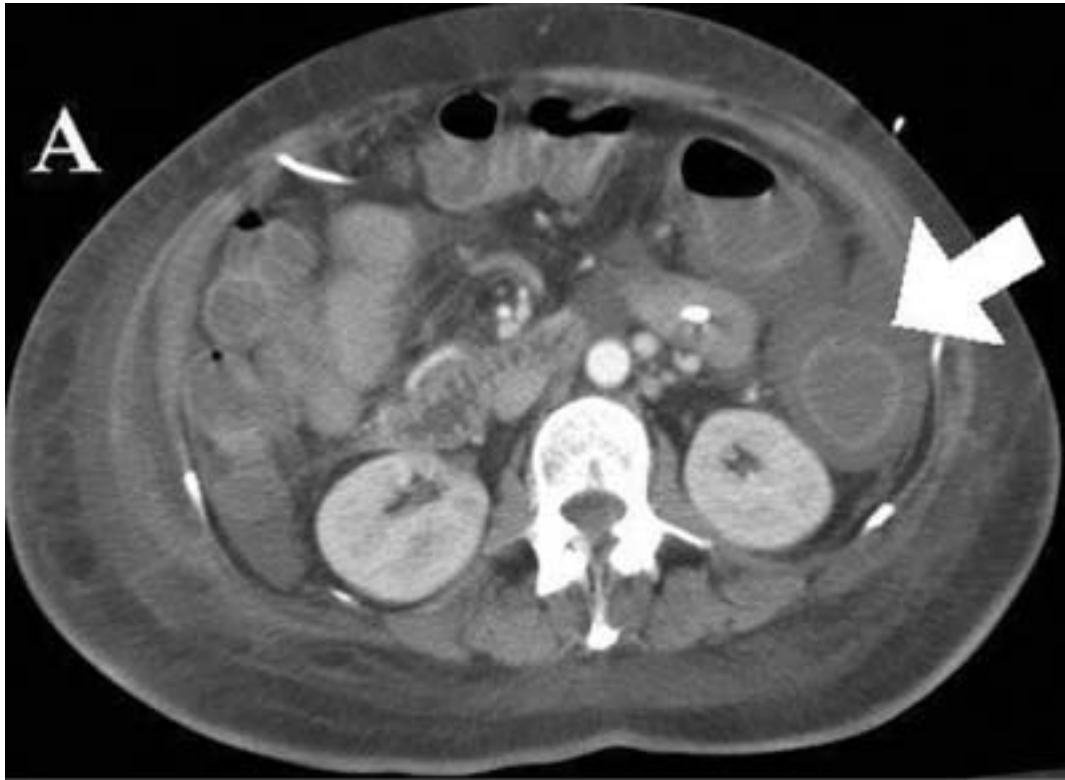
A: Abdominal CT scan with intravenous contrast performed on the day the patient developed decreased mental status. The image demonstrates diffuse colon wall thickening and edema (arrow) and ascites. B: Abdominal CT scan with oral and intravenous contrast taken two weeks later displaying a marked interval improvement in colon wall thickening and ascites.
